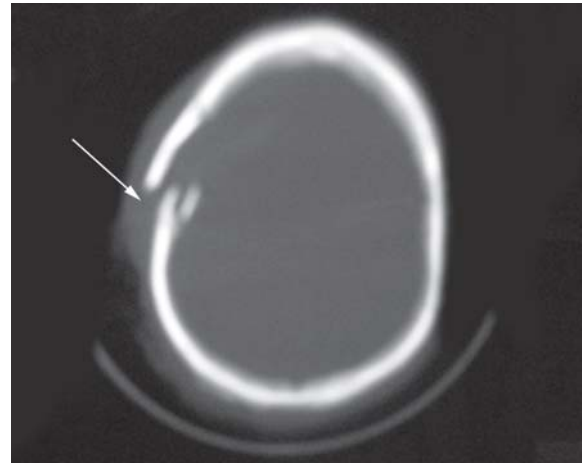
CT scan of the head showing depressed fracture of skull
